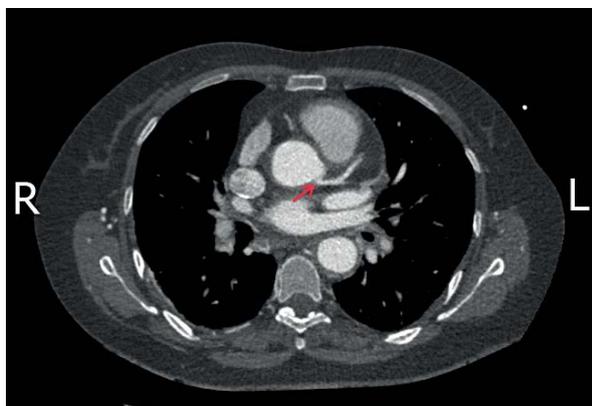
CT scan of the aortic root (axial plane). Suspect of left main coronary artery ostial stenosis (red arrow)
